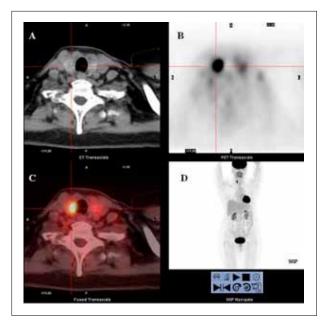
F-18 FDG PET/CT axial images showed focal intense hypermetabolic right thyroid nodule (A, B, C, and D represent CT, PET, fused PET/CT and maximum intensity projection images respectively).
